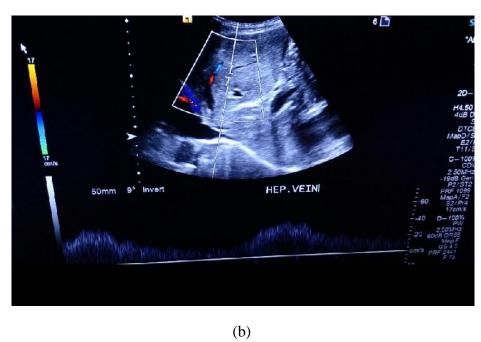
(a&b): Spectral Doppler USG Image of Hepatic vein
